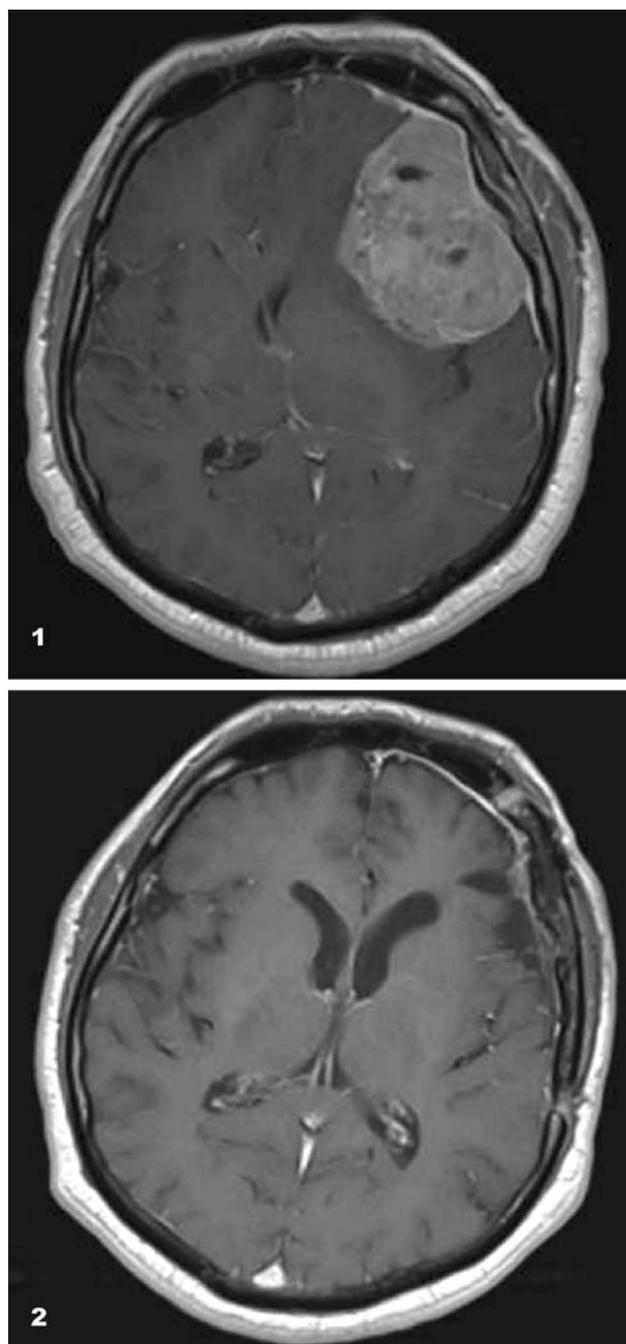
MRI T1WI post-contrast axial images show a large left convexity meningioma with mass effect and midline shift. Figure 2 is the post-operative MRI images showing complete excision and resolution of mass effect.
